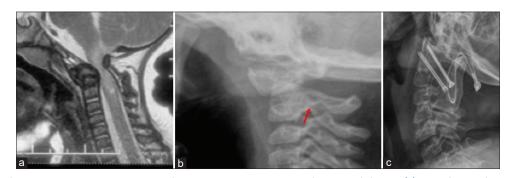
Midsagittal T2W magnetic resonance imaging showing severe compression with T2W cord changes (a). Lateral cervical spine X-ray (b) showing the atlantoaxial dislocation (AAD) and narrow C2 pars (red arrow). Follow-up (57 months) lateral X-ray (c) showing the reduced AAD with good bony fusion
